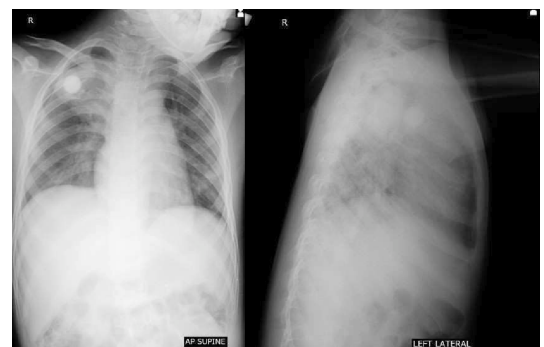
Initial chest radiograph at the emergency room. Round radiopaque material which was thought to be a foreign body (marble) at the right upper lung, with fracture of the fourth posterior rib. AP, anteroposterior; LAT, lateral.
